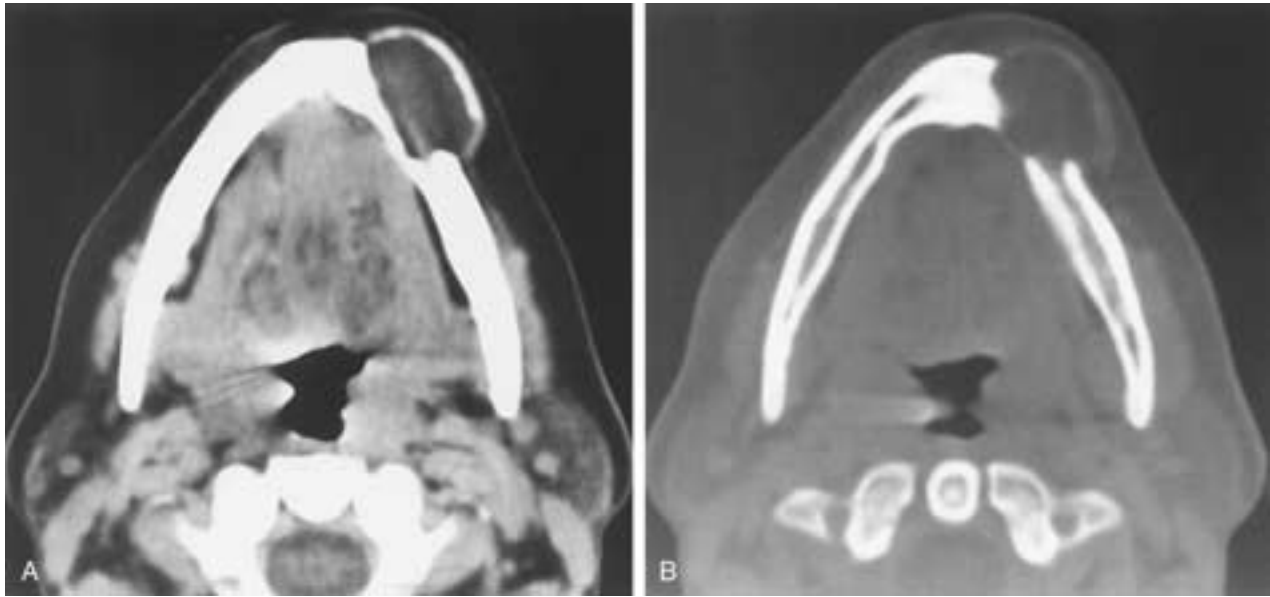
Ameloblastoma. A, Axial CT (soft-tissue window setting) shows an expansile lesion in the body of the left mandible and adjacent symphysis with marked lateral expansion. B, Axial CT (bone window setting) defines the boundary of this expansile lesion to better advantage. Also, note the erosion of the lingual surface of the mandible.
